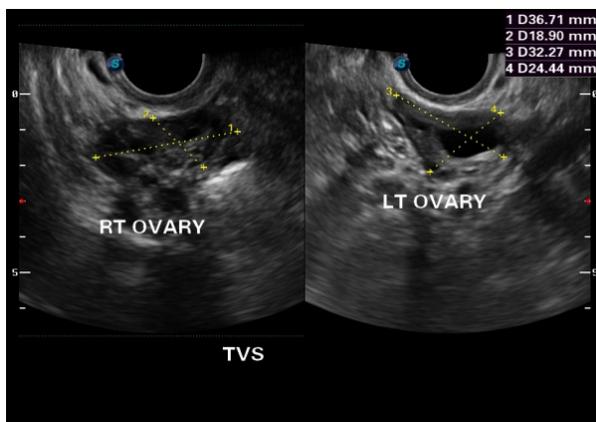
Transvaginal ultrasound image of ovaries (arrows) showing follicles in fertile group.
